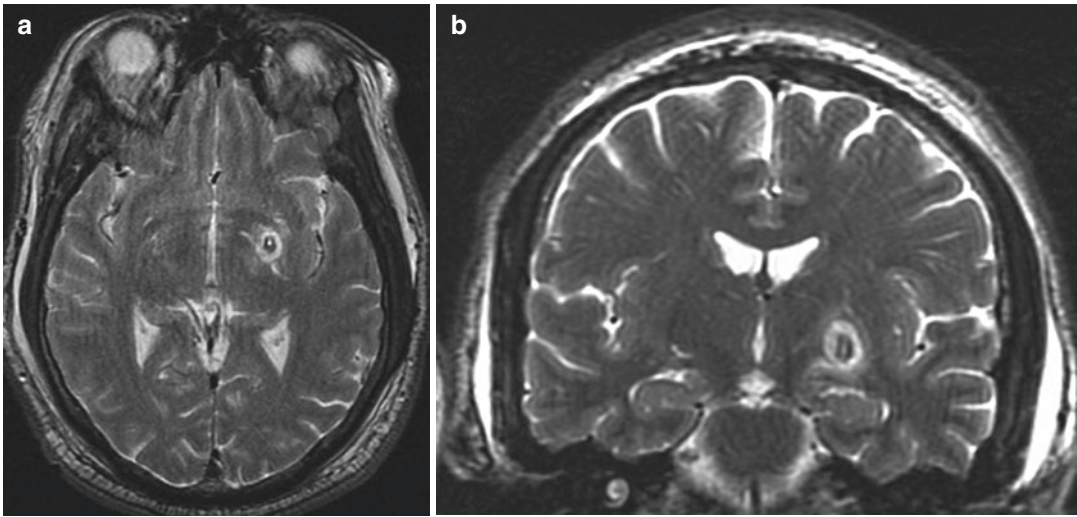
T2-weighted MR images of a radiofrequency pallidotomy 24 hours post-procedure in the axial (a) and coronal (b) planes. Note the location of the lesion just lateral to the internal capsule and above the optic tract
